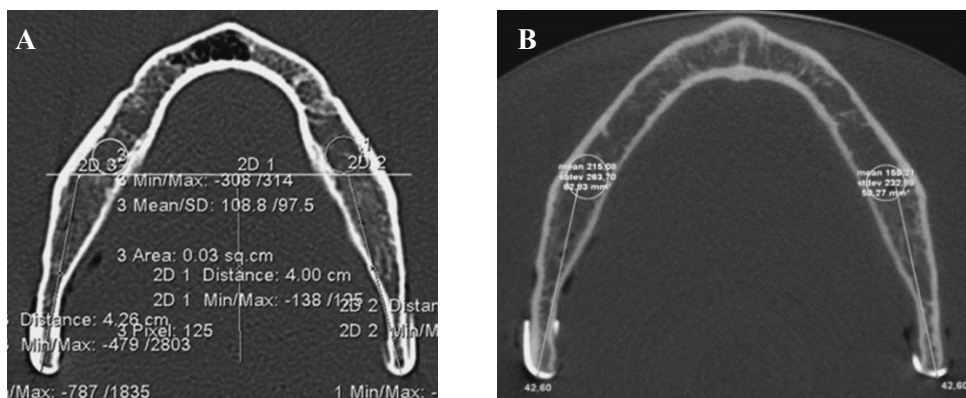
Axial images of a scanned mandible with conventional CT (A) and CBCT (B) (141)
